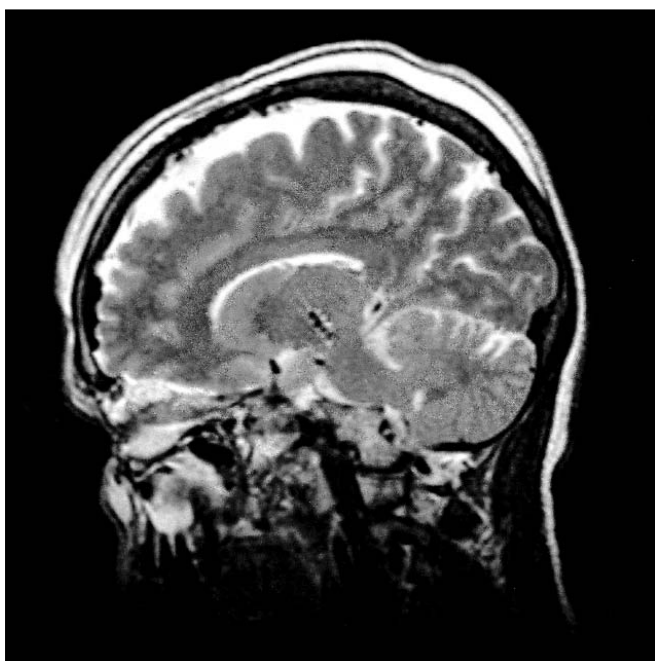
T2 weighted sagittal MRI image showing position of subthalamic nucleus deep brain stimulating electrode.
